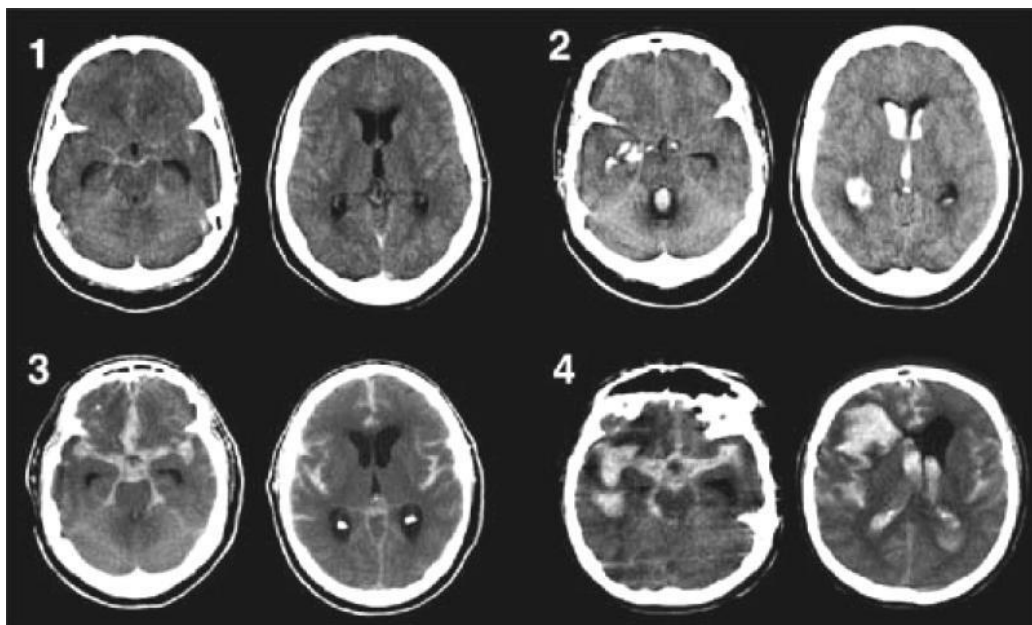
The Modified Fisher CT rating scale: Grade 1 (minimal or diffuse thin SAH without IVH), indicating low risk for symptomatic vasospasm; Grade 2 (minimal or thin SAH with IVH) and Grade 3 (thick cisternal clot without IVH), indicating intermediate risk for symptomatic vasospasm; and Grade 4 (cisternal clot with IVH), indicating high risk for symptomatic vasospasm.⁽²²⁾
